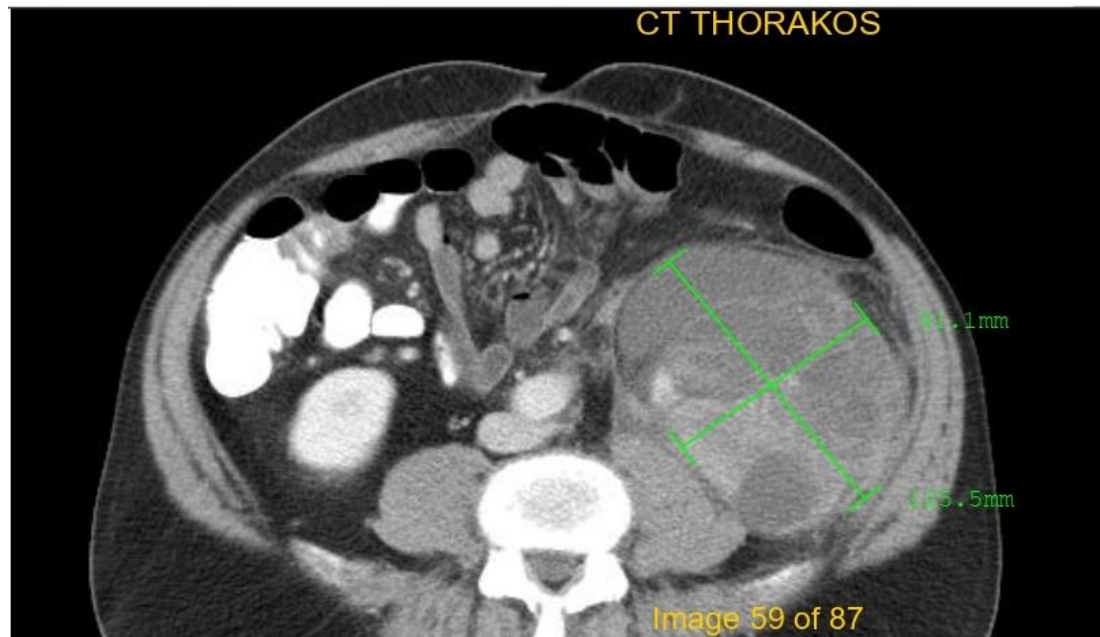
62-year-old man with recurrent retroperitoneal liposarcoma; CT scan shows soft-tissue mass in retroperitoneum. Longest diameter is 12.5 cm
